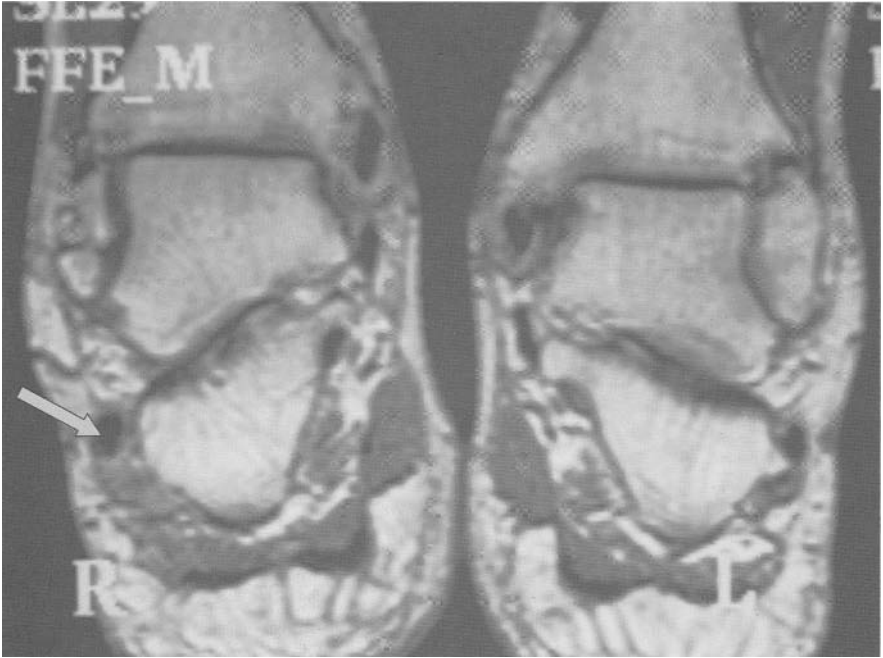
MRI: T1 fat sat gadolinium. Pannus of the sheath of the ptt. No pathology of the tendon itself (fig. a and fig. b).
